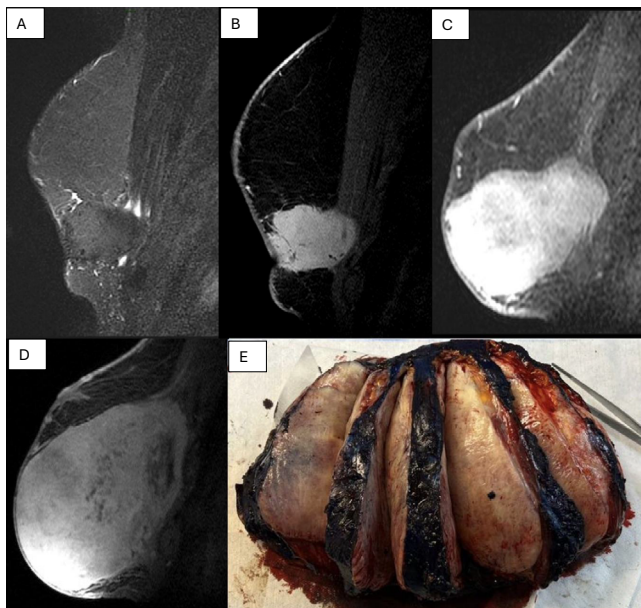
Contrast-enhanced sagittal T2-weighted sequence at breast MRI demonstrating an oval mass with irregular margins, presenting low signal and peri tumoral edema on T2-weighted images (A), infiltrating the pectoral muscle, and showing heterogeneous enhancement in sagittal fat-suppressed contrast-enhanced T1-weighted images (B). The lesion progressed despite the systemic treatment after seven months (C) and eleven months (D). The patient underwent a mastectomy with a partial resection of the underlying musculature (E).
